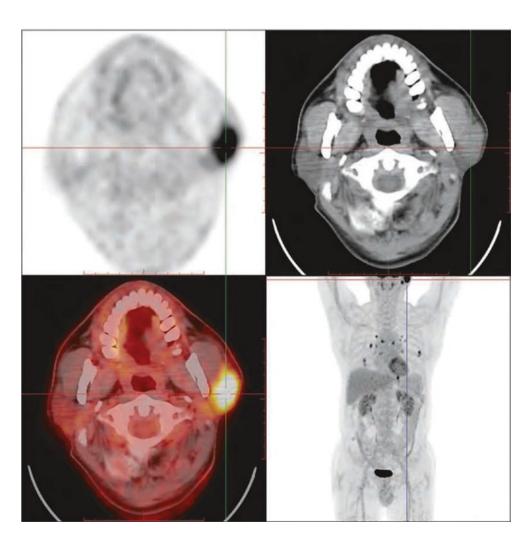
¹⁸F-FDG PET/CT images of left salivary duct carcinoma. A round soft tissue mass was found in the left parotid gland area. Its internal density was inhomogeneous and the boundary was not clear. The
